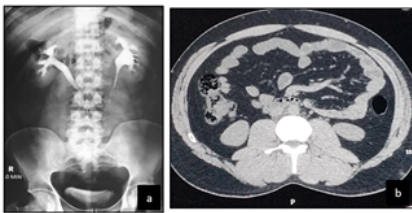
26 Y/M, c/o right loin pain since 3 months, (a) IVU showing 'J' shaped right ureter and mild right hydronephrosis, (b) CT axial image showing retrocaval ureter.
